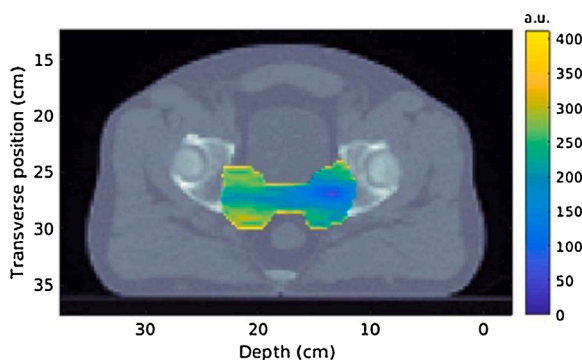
Example error mask  $\varepsilon(i,j)$  corresponding to each pencil beam in the dictionary (eq. 4), overlaid on a CT axial image, for a set of 4 signals, which in this example case are taken from the dictionary  $\{D_1(t; 13.5; 27), D_2(t; 13.5; 27), D_3(t; 13.5; 27), D_4(t; 13.5; 27)\}$ , captured at detectors placed on positions referred to in Fig. 3. Within this mask, dark blue represents lowest values of error, *i.e.* positions where it is most likely to find the Bragg peak, and yellow represents highest values of error, that is positions situated further away from the Bragg peak, according to the measured signals. (For interpretation of the references to colour in this figure legend, the reader is referred to the web version of this article).
